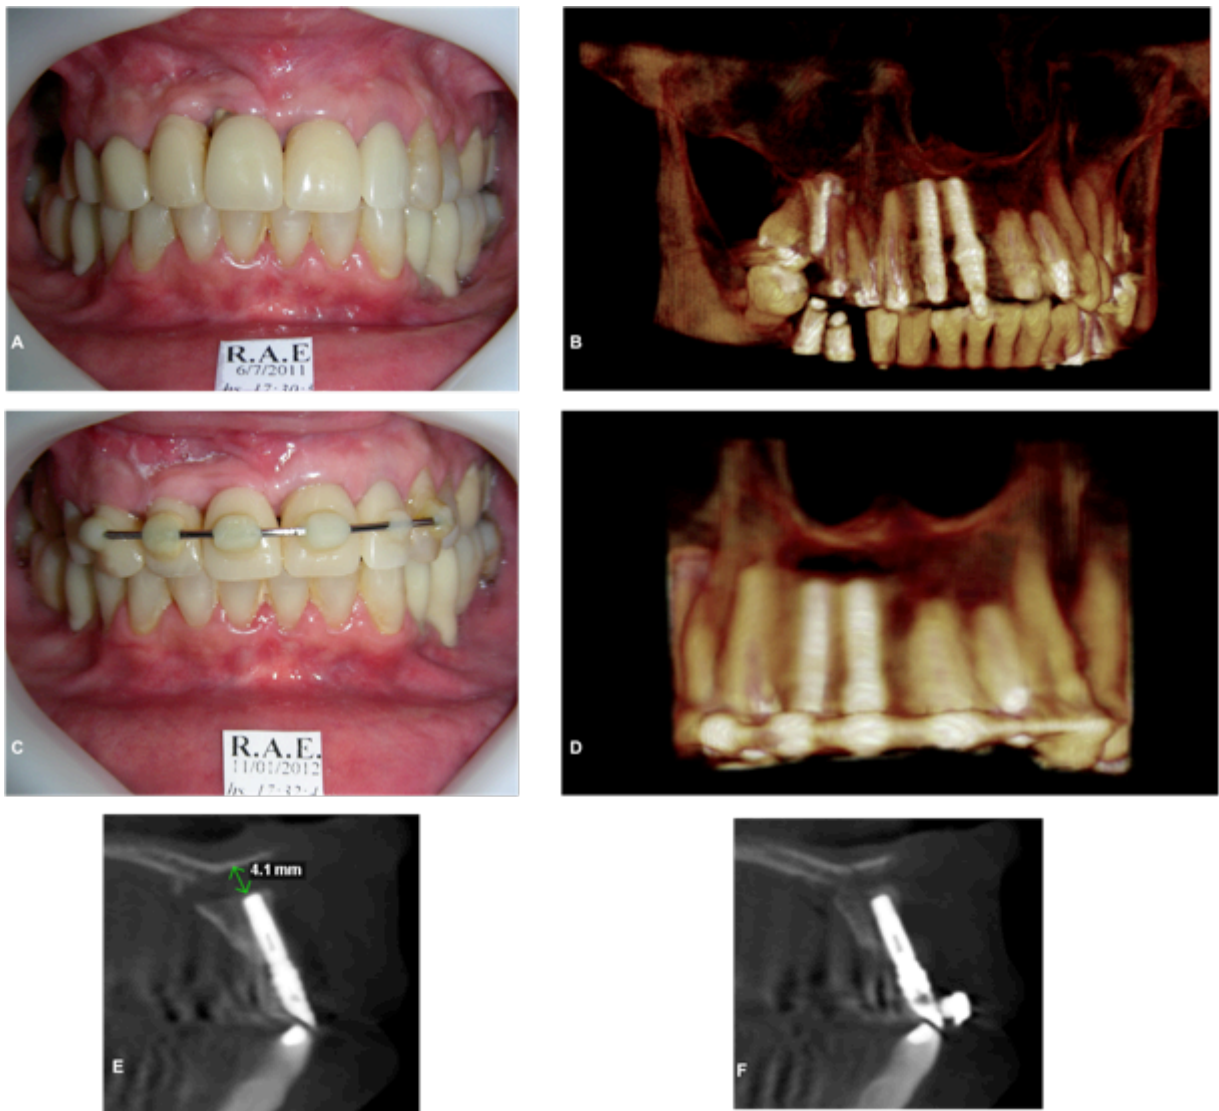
A 62-year-old female patient who underwent implant-bone block osteodistraction at the site of the maxillary right central and lateral incisors. A: The clinical frontal intraoral view showing the absence of papillae between the implant and an elongated lateral incisor; B: A 3D reconstruction of a CBCT image showing vertical alveolar bone atrophy at the site of the implants; C and D: The clinical frontal intraoral view and 3D CBCT reconstruction of the after bone-block osteodistraction showing partial formation of papillae between the implants and an improved length of the crowns; E and F: A sagittal slice from the site of the maxillary right incisor with a bone gap of 4.1 mm that was partially filled with new bone in T3.
